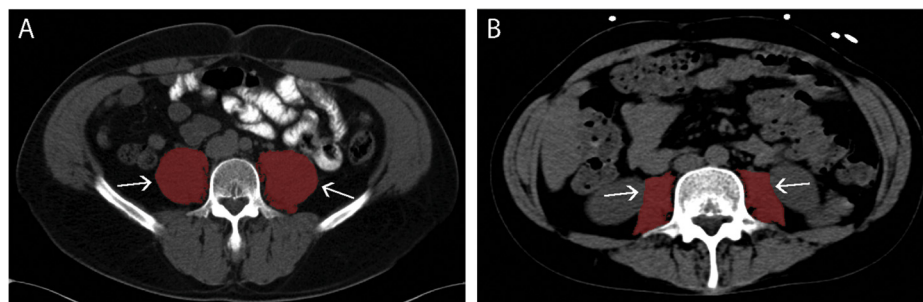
Cross-sections of psoas muscles on computed tomography. Axial computed tomography image of the abdomen was obtained preoperatively. 3D Slicer was used to highlight the psoas major muscles at L4 (arrows). (A) A patient who is not sarcopenic and (B) a sarcopenic patient.
